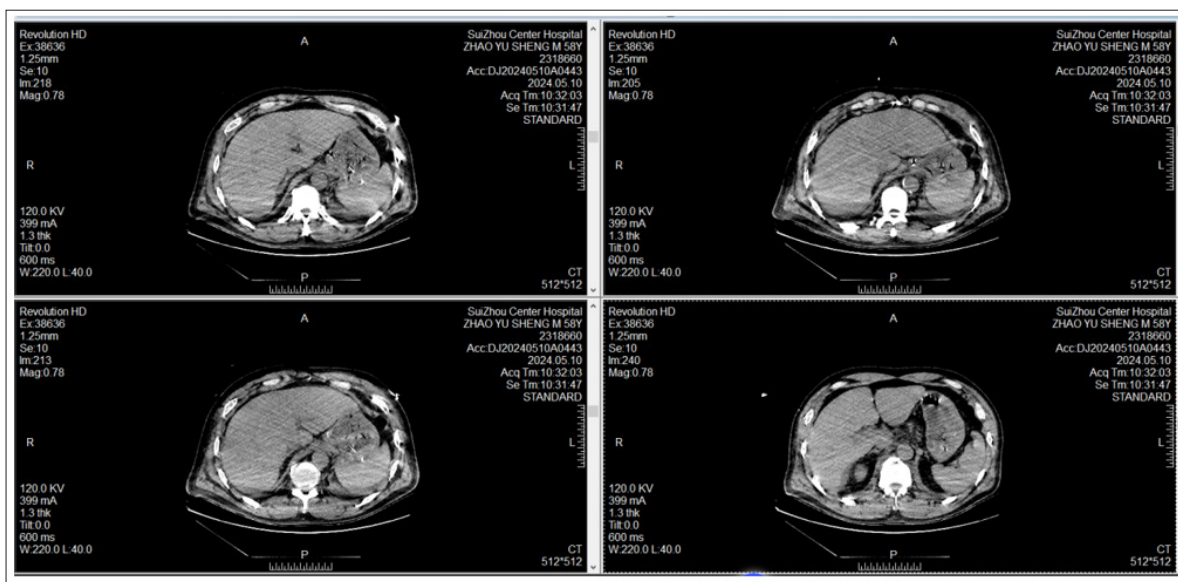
CT on May 10 showed calcification and suspicious dissection in the descending aorta.Lower abdominal and pelvic effusion (hematosis), compared with May 9, new, it is recommended to combine clinical and review
